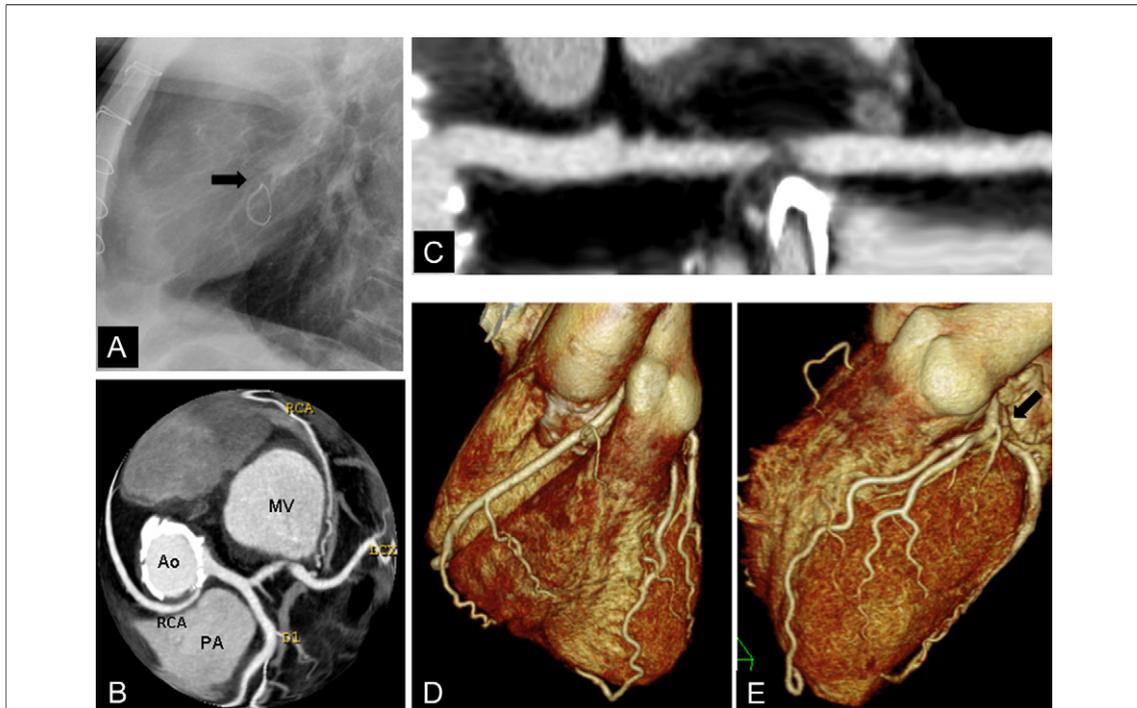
CT Imaging of the Coronary Abnormalities
